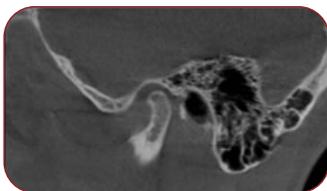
a. CBCT oblique sagittal section of the left TMJ with closed mouth: condyle cortical osteophytes and no other notable changes
